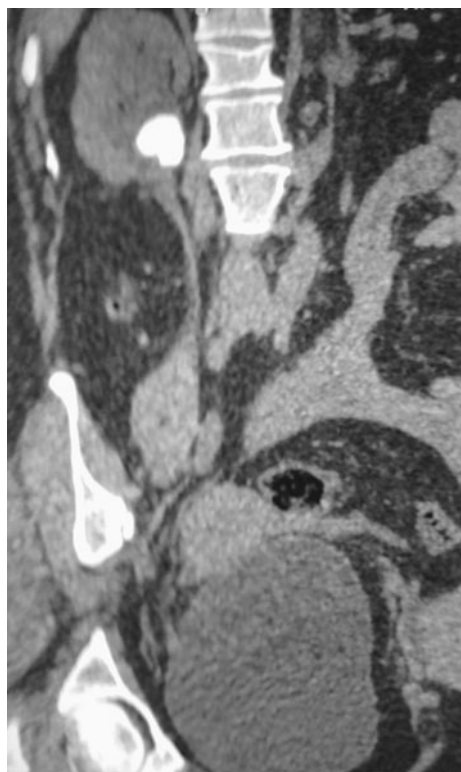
Preoperative CT image of stone pelvis RT kidney
